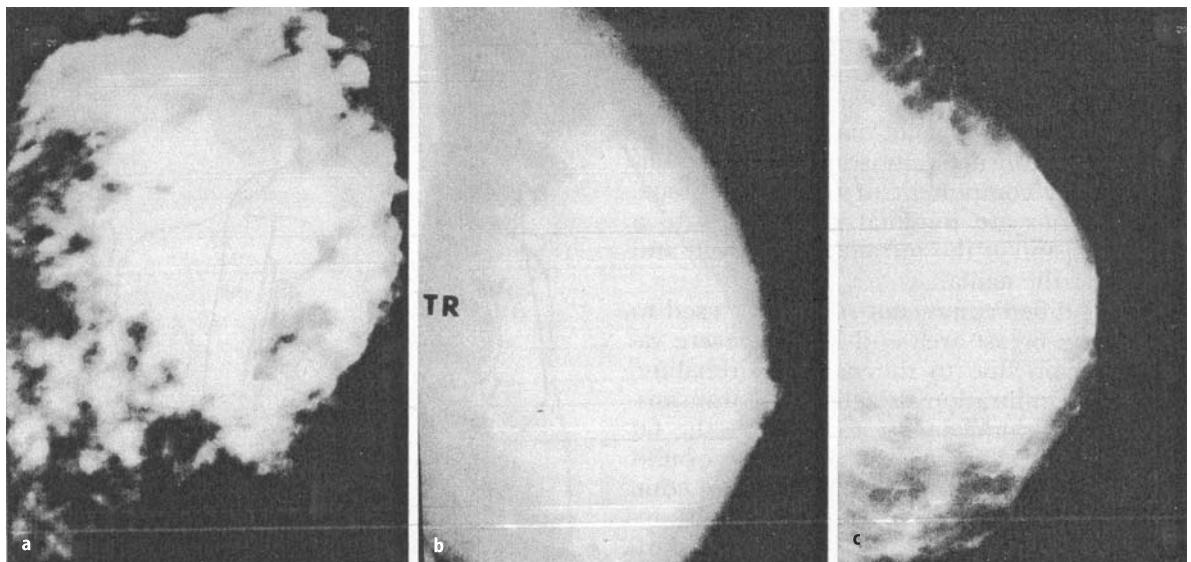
Preoperative mammographic evaluations are used to identify candidates for ultrasound-assisted lipoplasty and breast reduction. a Typical fibrotic glandular tissue; this patient is not a candidate. b Typical fatty breast; this patient is an ideal candidate. c Fibro-fatty mixed gland; the patient is a candidate for lipoplasty of the posterior cone and upper and lower quadrants
